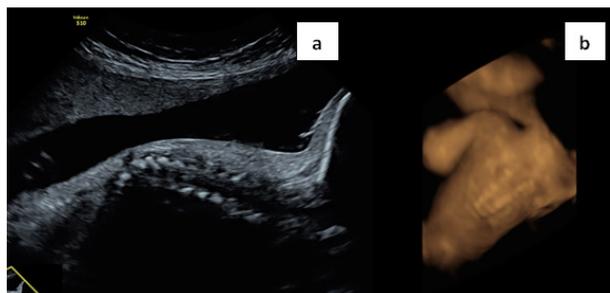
Ultrasound week 30. a) Sagittal section of the column in 2D b) 3D image.
